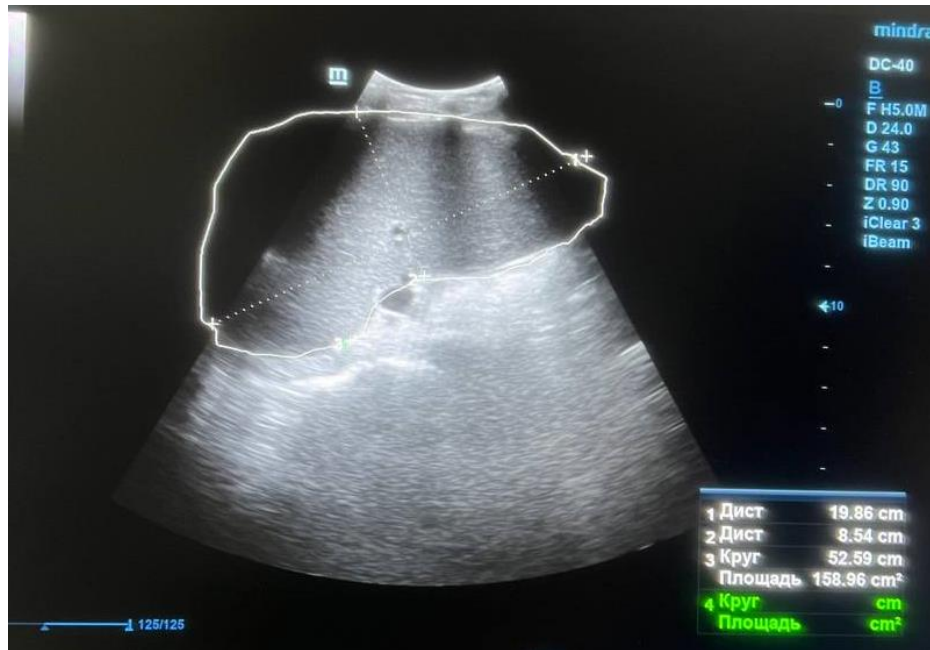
Ultrasound examination. Spleen size increased up to 159 cm².
